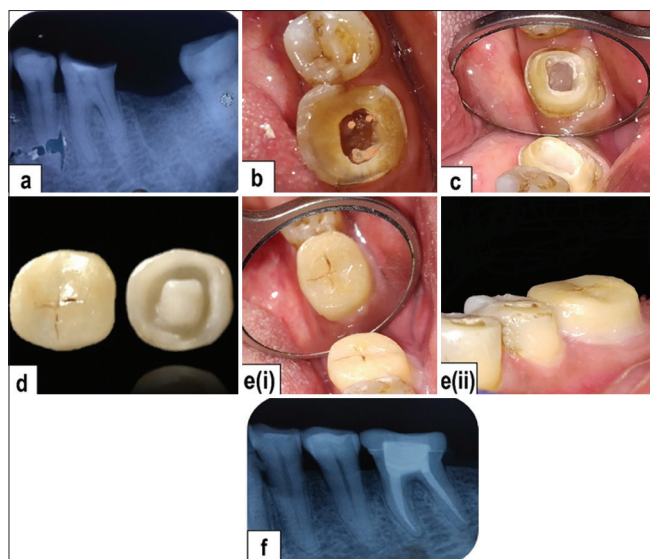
Procedural steps: (a) Pre-operative radiograph, (b) post-obturation clinical image, (c) tooth preparation (d) lithium disilicate endocrown (cameo and intaglio surfaces), (e) bonded endocrown restoration: i) occlusal view, and ii) buccal view, and (f) post-operative radiograph
